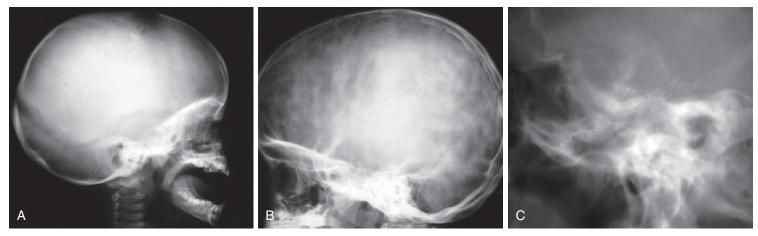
Findings of increased intracranial pressure that may be seen on standard skull radiographs. A, Widening of the cranial sutures. B, Prominent convolutional markings on the inner table of the skull (beaten silver skull). C, Erosion of the sella turcica, in this case resulting from a craniopharyngioma. (A, Courtesy Department of Neuroradiology, University Health Center of Pittsburgh, Pittsburgh, Pa; B and C, courtesy Jocelyn Medina, MD.)
